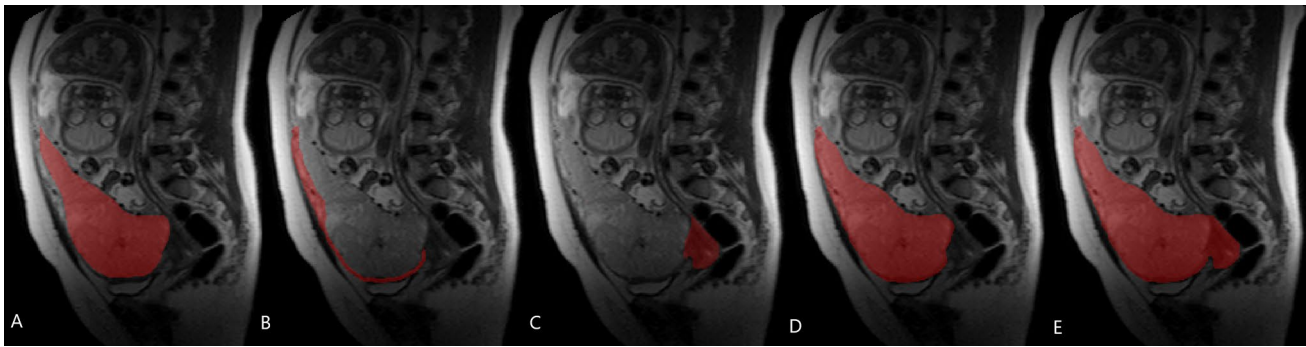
An example of ROI delineation on the different uteroplacental anatomical structures of the same patient in T2-weighted sagittal images: a placental tissue; b retroplacental myometrium; c cervix; d
